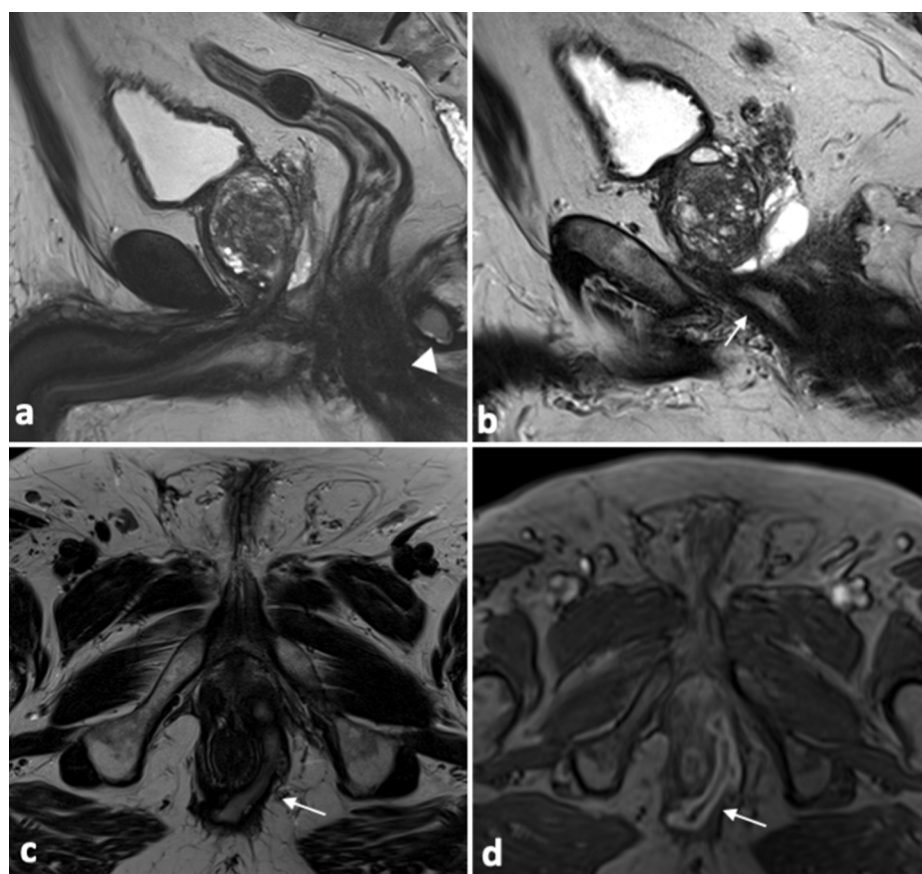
Midline sagittal T2w image (a) shows a perianal abscess (arrowhead), while left paramedian sagittal (b), axial (c) T2w images and axial DCE image (d) show inter-sphincteric and *trans*-sphincteric fistulous tracts towards the prostate (arrows). T2w T2-weighted, DCE dynamic contrast enhanced.
